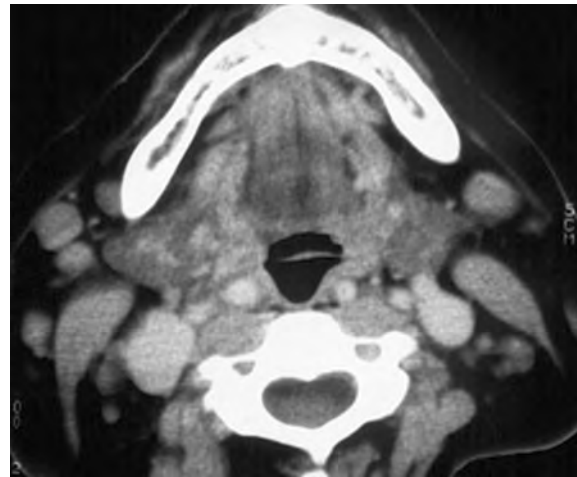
Secondary parotid lymphoma. Axial contrast-enhanced CT-image shows multiple sharply marginated masses within and around both parotid glands representing enlarged intra- and peri-parotid lymph nodes (Courtesy R. Hermans, MD, PhD, Leuven, Belgium)
